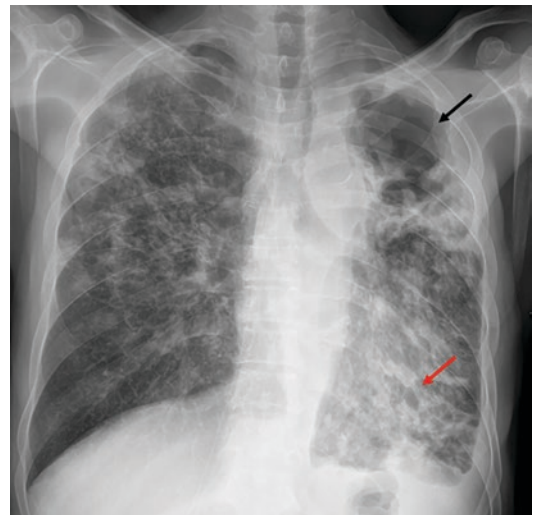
Tuberculosis reactivation in a 59-year-old man. PA chest radiograph shows a cavitating consolidation in the left upper lobe (black arrow) and multiple ill-defined and confluent nodules in both lungs. Note bronchiectasis in the left lower lobe (red arrow)
